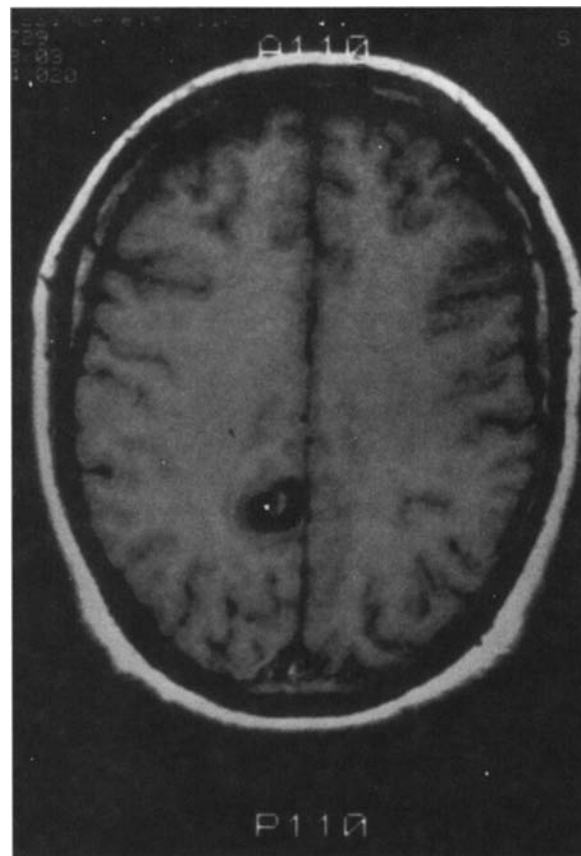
Axial T₁-weighted MRI shows a right posterior parietal active cyst in a 29-year-old man with tonic clonic generalized seizures. Some edema surrounding the cysts may represent inflammation. The scolex is visible in the cyst as a hyperintense structure.
